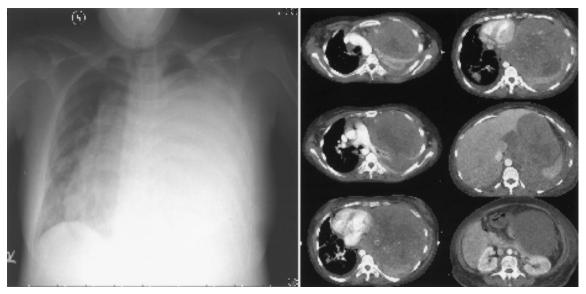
Three months later, the tumor was enlarged with the mediastinum shifting to the right side,  $23 \times 18 \times 16$  cm in size. Multiple enlarged paratracheal and celiac lymph nodes were also noted, and metastasis was suspected on chest radiography and computerized tomography.
